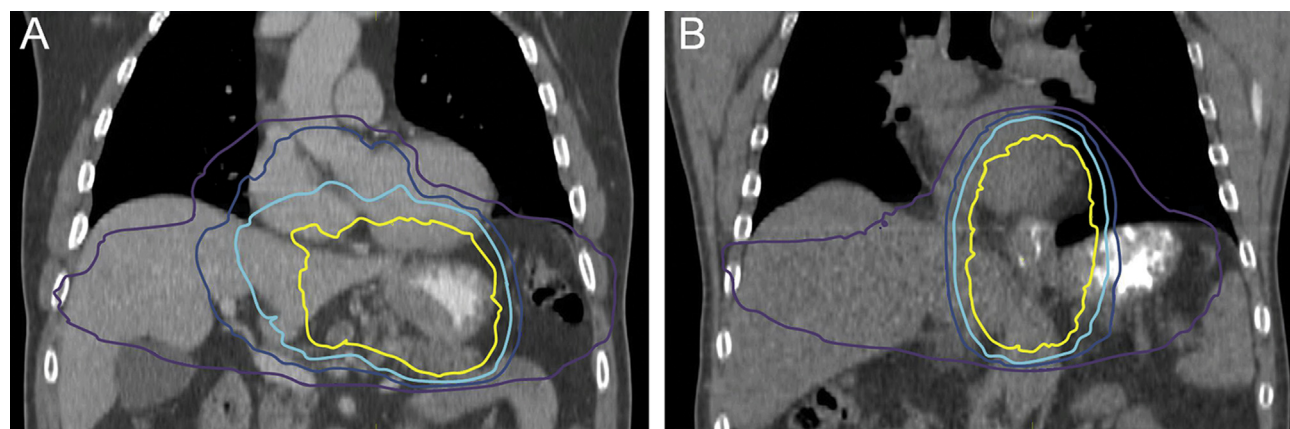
Examples of treatment planning computed tomographic (CT) scans with dose distributions in (A) a patient who experienced postoperative anastomotic leakage after receiving a mean dose to the gastric fundus of 41.2 Gy and (B) a patient who did not experience postoperative anastomotic leakage after receiving a mean dose to the gastric fundus of 11.8 Gy. The areas within the yellow, light blue, dark blue, and purple lines received at least 40, 30, 20, and 10 Gy, respectively.
